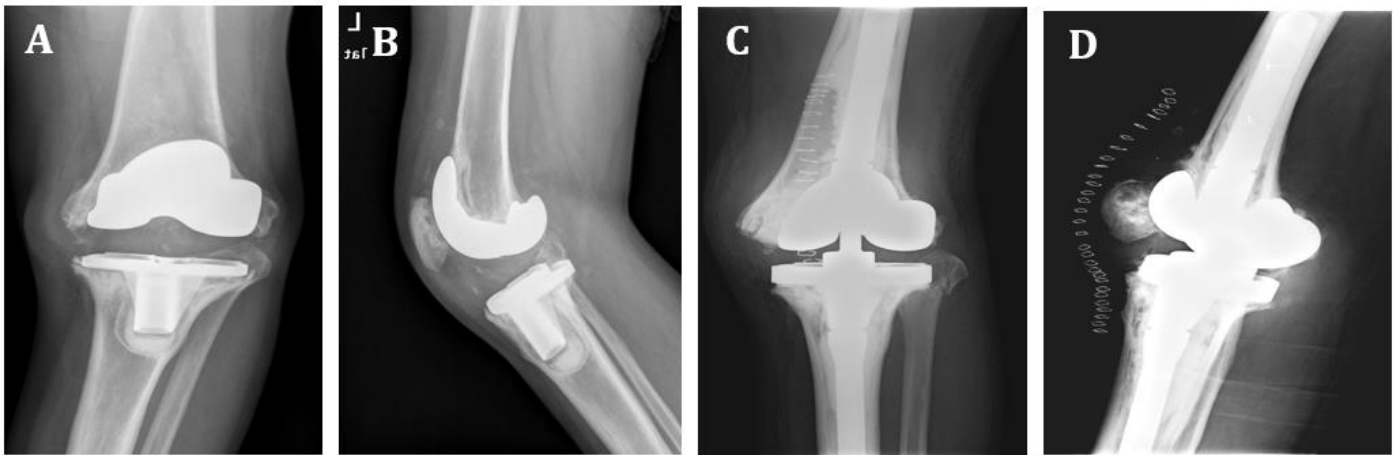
(A-D). Radiographic images of an aseptic loosening of a primary total knee arthroplasty (pTKA) that required one-stage revision total knee arthroplasty (rTKA) by means of a rotating hinge implant in a patient with hemophilia: (A) Preoperative anteroposterior (AP) radiograph; (B) Preoperative lateral view; (C) Postoperative AP radiograph; (D) Postoperative lateral view
